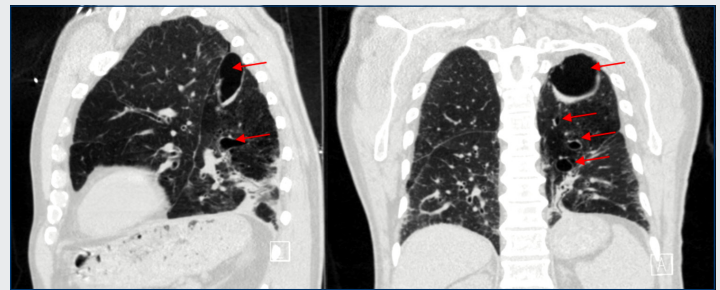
CT scan of lung showing a large bulla/pneumatocele in left upper lobe and smaller cysts in left lower lobe.
